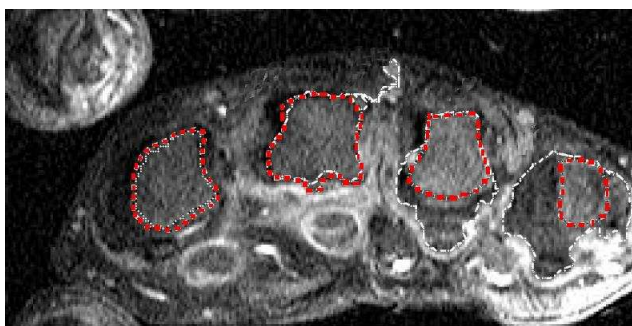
Four regions corresponding to bone interiors segmented in a sample DCE-MRI image. Machine segmented regions are shown in white, GT in red.
